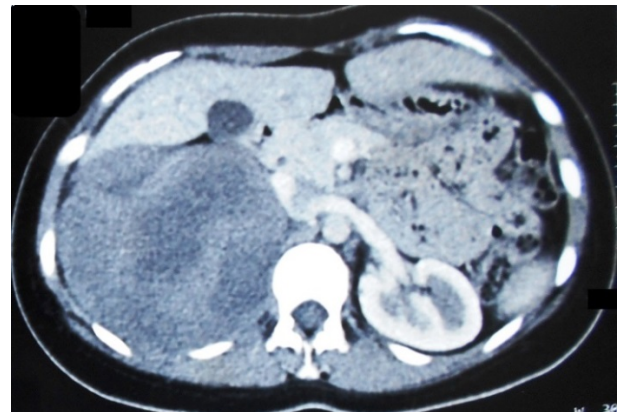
Coronal CT images showing large hypodense mass arising from upper and mid pole of right kidney (HU-24).
